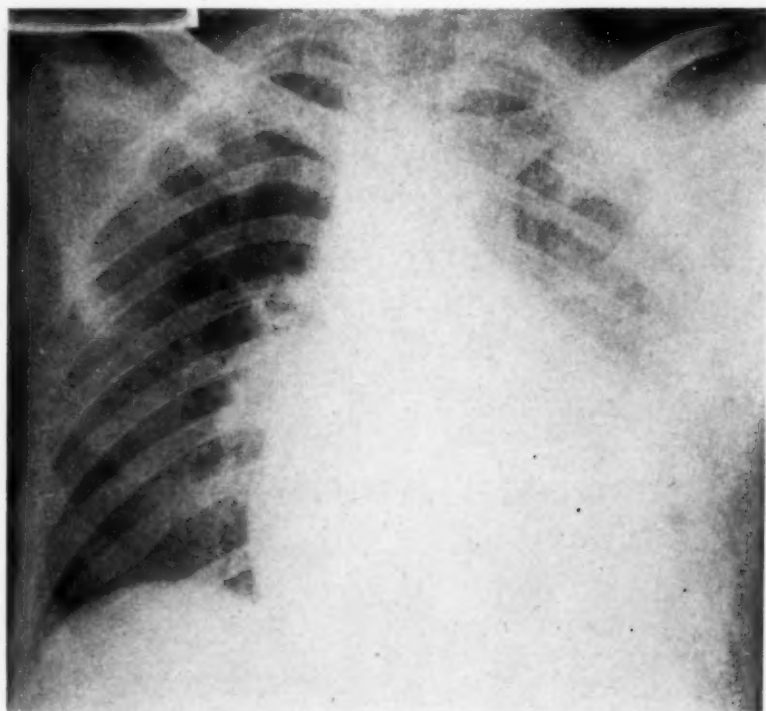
Portable chest roentgenogram taken December 5, 1943, shows a marked increase in the cardiac shadow with the left border of the heart shadow extending to the left thoracic cage.
